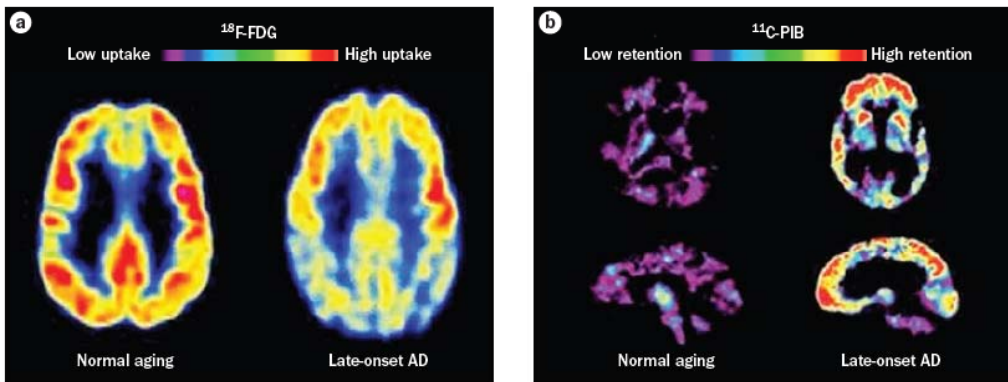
Changes revealed by PET in the AD brain. a | ¹⁸F-FDG-PET patterns characteristic of metabolic activity in cognitively normal individuals and patients with late-onset AD. In comparison with people aging normally, individuals with late-onset AD show decreased bilateral glucose metabolism, particularly in the temporal and parietal regions. b | ¹¹C-PiB PET images characteristic of elderly individuals without cognitive impairment and patients with late-onset AD. The high concentrations of ¹¹C-PiB in the AD brain are suggestive of high amounts of amyloid deposits. Abbreviations: AD, Alzheimer disease; FDG, 2-fluoro-2-deoxy-D-glucose; PiB, Pittsburgh compound B.
